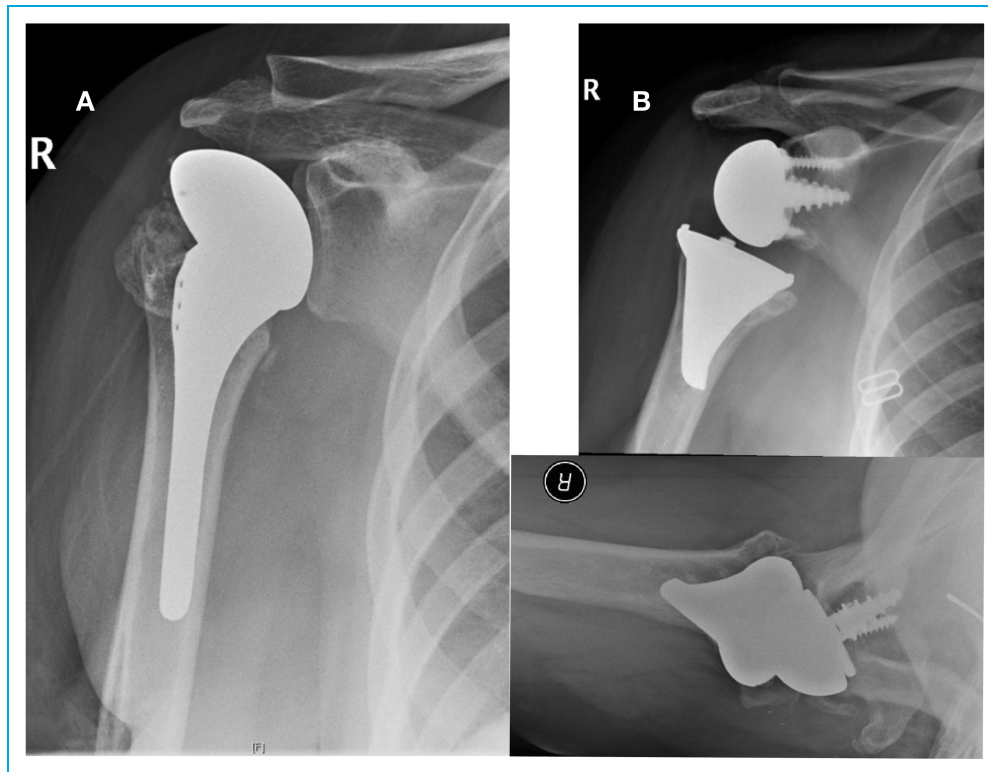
(Patient 4). (A) The stemmed Biomet Nottingham Hemiarthroplasty. (B) X-rays at last follow-up, over 12 years after the revision TSA, showing formation of new bone in the metaphysis and the medullary canal.
